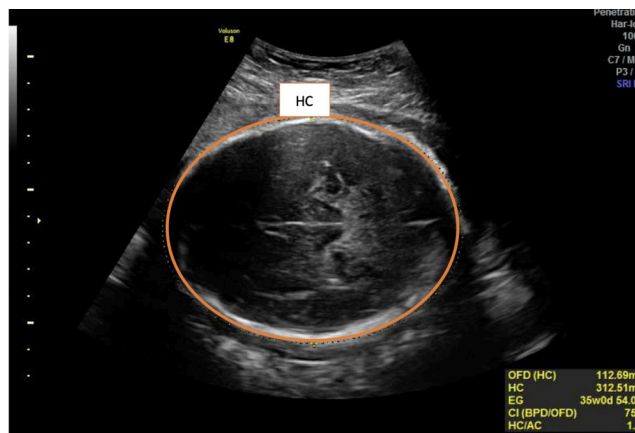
HC measurement by ultrasound (78)
